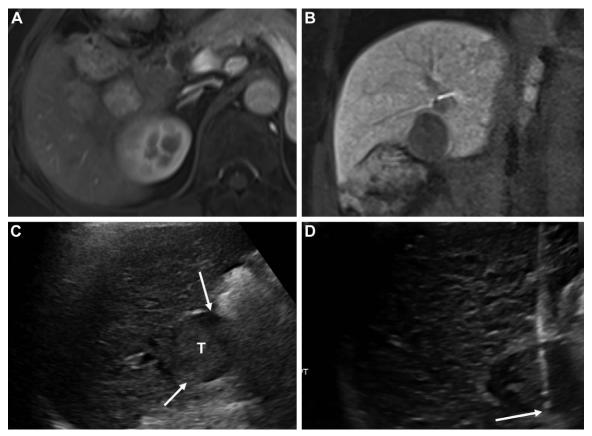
Conversion to tumor puncture radiofrequency ablation (RFA) in a 59-year-old woman with 2.5-cm hepatocellular carcinoma (HCC) and hepatilits B-related cirrhosis. (A) Arterial phase axial gadoxetic acid-enhanced MRI shows a 2.5-cm enhancing nodular lesion in segment VI subcapsular portion of the liver, indicating HCC. (B) On a coronal hepatobiliary phase image, the tumor shows low signal intensity abutting to hepatic flexure colon. (C) Target tumor appeared as low echoic nodular lesion on B-mode US. The half of tumor is not covered by liver parenchyma, indicating insufficient peritumoral liver parenchyma (T indicates the target tumor; arrows indicate the margin of target tumor). (D) Because of the lack of a safe access route for multiple radiofrequency electrodes insertion in the peritumoral region, conversion to tumor puncture RFA was done to treat HCC (arrow indicates the electrode tip within target tumor).
